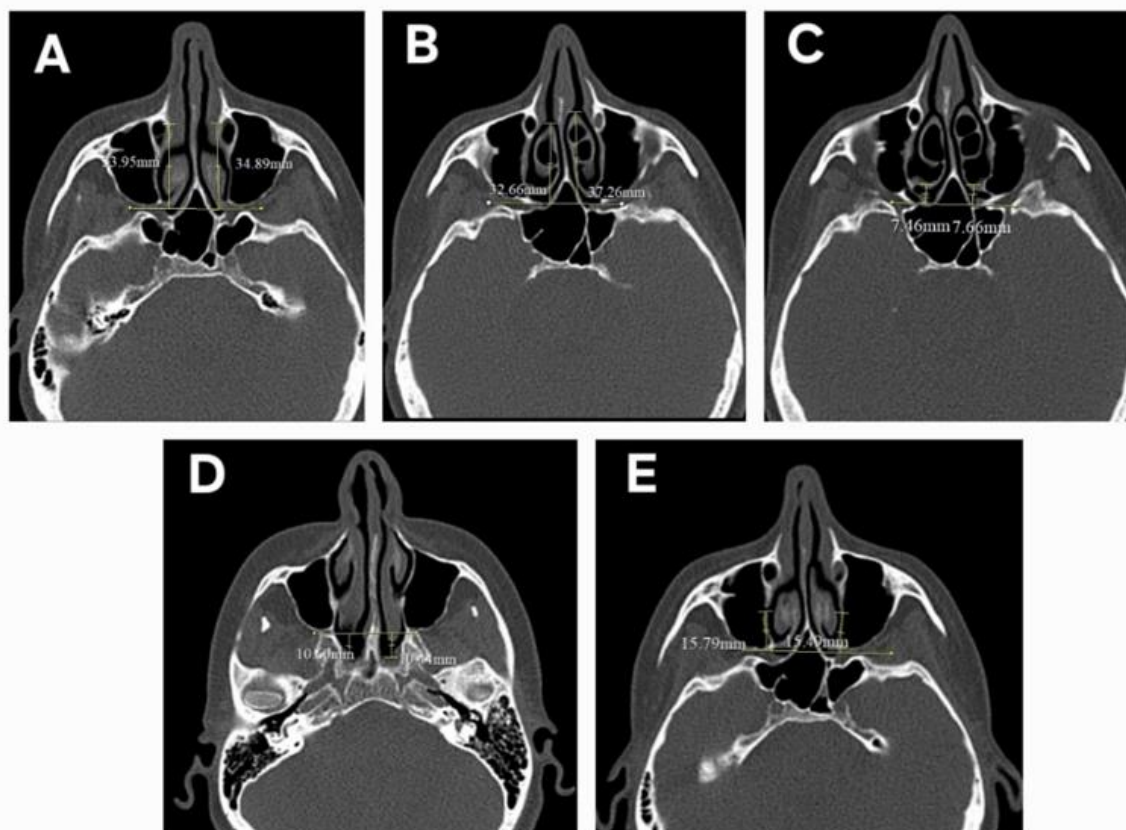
Computed tomography measurements for distances between sphenopalatine foramen and maxillary line (A), anterior head of the middle turbinate (B), basal lamella (C), choanal arch (D), posterior fontanel (E).
